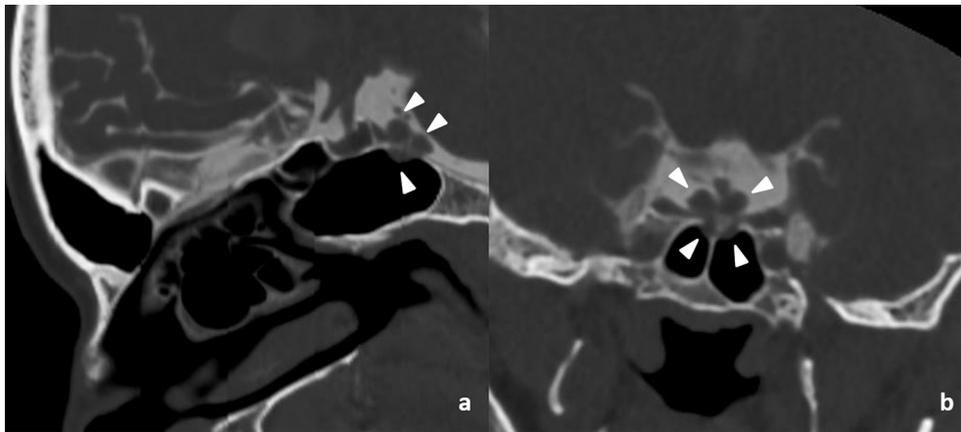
Thirty-two-year-old woman with watery nasal discharge on both sides: a–b: coronal and sagittal CT cisternography images in bone window shows a lobulated soft tissue lesion in preoptine cistern with bony erosion and extension into sphenoid sinus on both sides, consistent with echordosis physaliphora (arrowheads).
